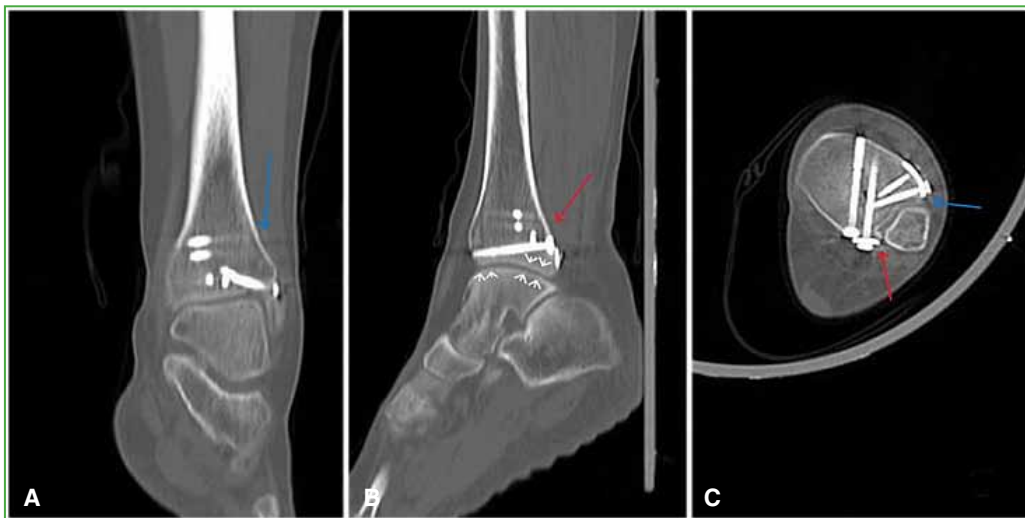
Computed tomography of the ankle at 12 months. A. Complete union of the Tillaux-Chaput fracture (blue arrow). B. Adequate healing of the Volkman fracture (red arrow), with slight narrowing of the tibiotalar joint space (white arrowheads). C. Concentric reduction of the fibula within the fibular notch. Stable internal fixation of the Tillaux-Chaput (blue arrow) and Volkman (red arrow) fractures.
